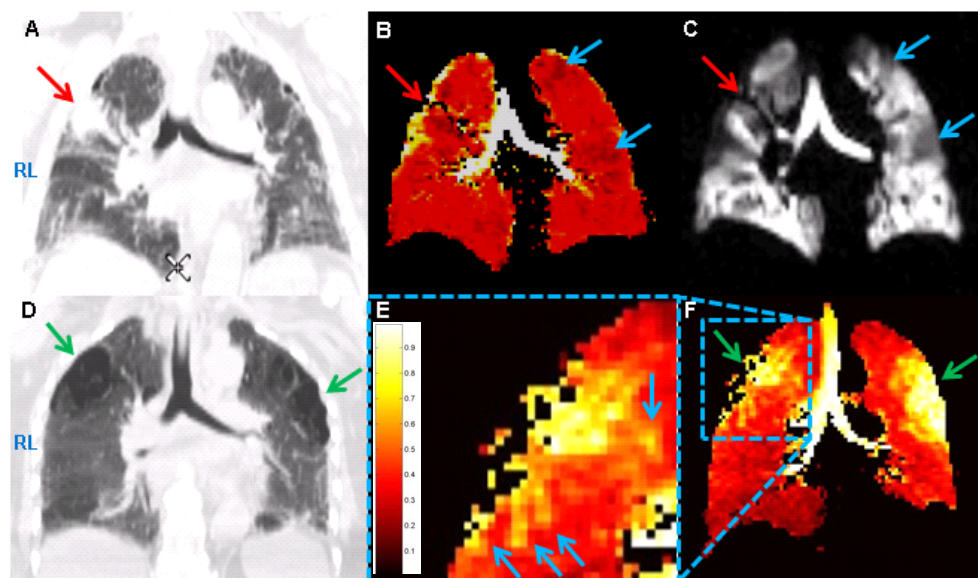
Images in top row belong to subject 1 (pulmonary fibrosis). Images in bottom row belong to subject 3 (COPD). A: CT scan showing carcinoma (red arrow), and fibrosis throughout both lungs. B: ADC map. Location of carcinoma (red arrow) is surrounded by areas of patchy fibrosis (low ADC) and honeycombing which produces elevated ADC values. Two larger patches of fibrosis are seen in the left lung (blue arrows). C: He-3 ventilation image shows a ventilation defect from the carcinoma (red arrow) and the underlying lung disease (e.g., blue arrows). D: CT scan showing two large areas of emphysema (green arrows). E: Zoom-in of the right lung upper lobe section of the ADC map in image F to show elevations in the form of protuberances (blue arrows). Scale represents ADC and is in cm²/s. Same ADC scale applies to all ADC maps. F: ADC map, showing both lungs and both emphysematous areas (green arrows) as seen in CT image D.
